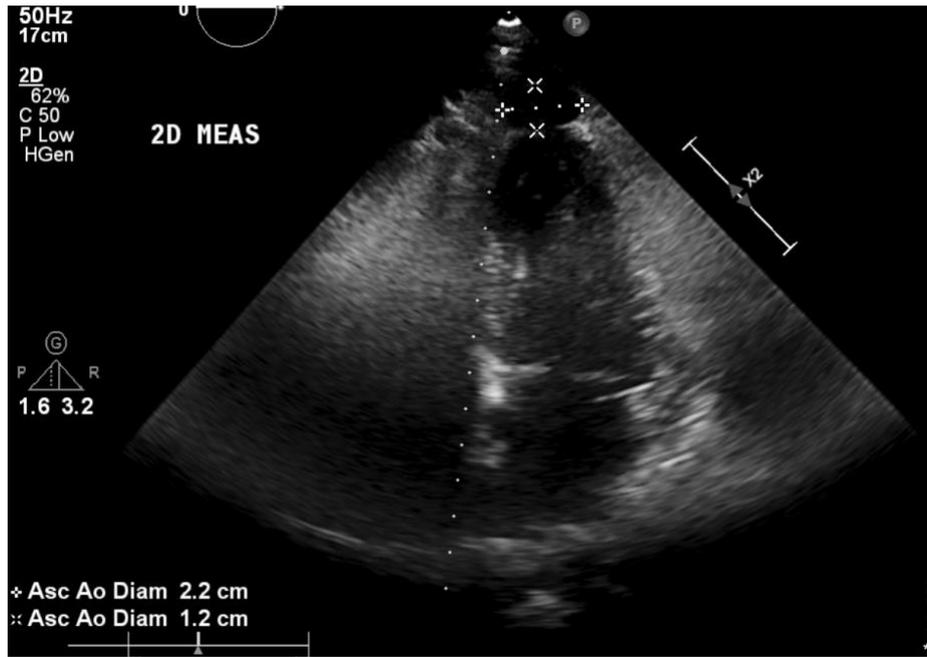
Trans thoracic Echocardiography (TTE) with suspected pseudoaneurysm.*
